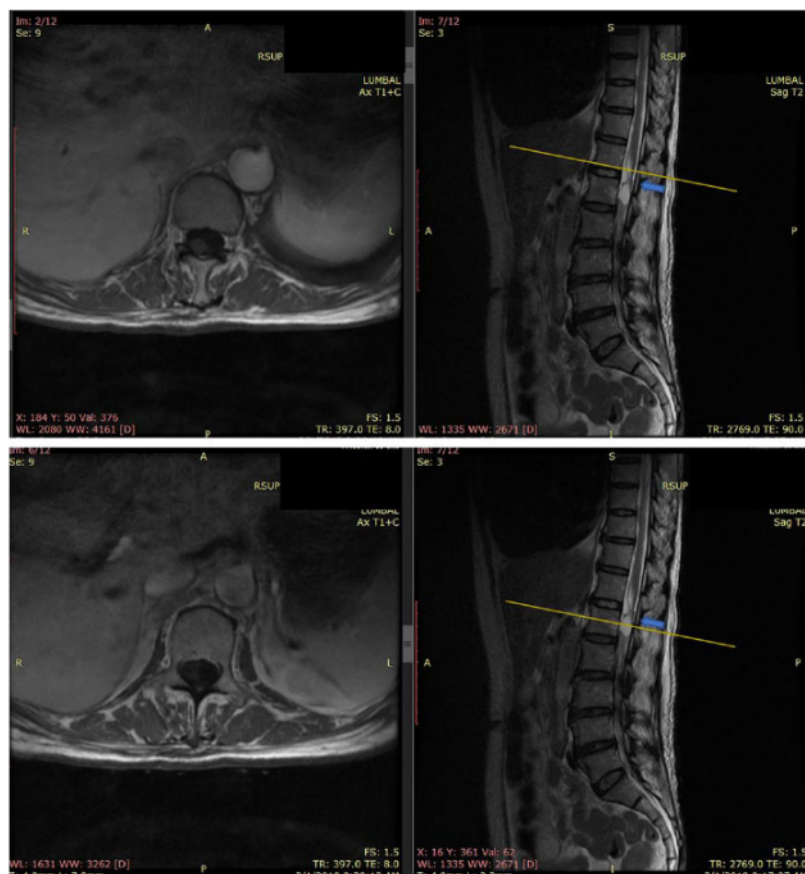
Magnetic Resonance Imaging (MRI) of patient with Schwannoma (blue arrow)
